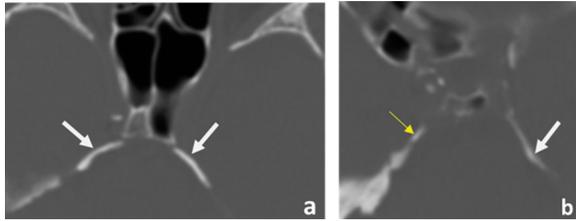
Bilateral ossification of petrosphenoid ligament (PSL); A. Axial computed tomography image showing bilateral complete ossification of PSL (white arrows) in a 52-year-old male; B. Axial computed tomography image showing partially ossified PSL on the right side (thin yellow arrow) and completely ossified PSL on the left side (thick white arrow) in a 68-year-old male.
